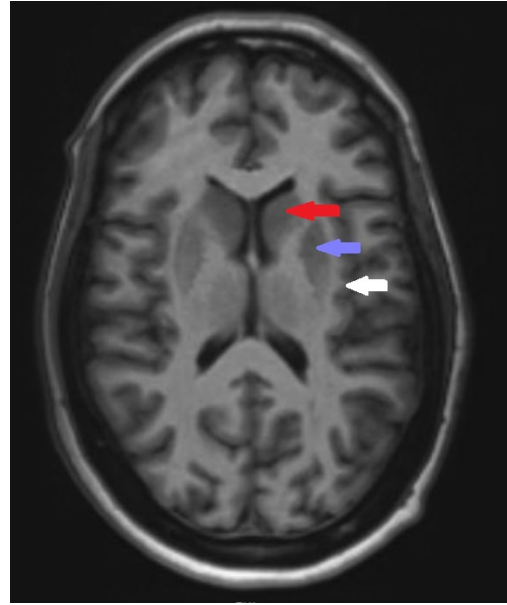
Axial T2-weighted FLAIR magnetic resonance image of the brain at the level of caudate (red arrow), putamen (blue arrow) and white matter of parietal lobe (white arrow).
